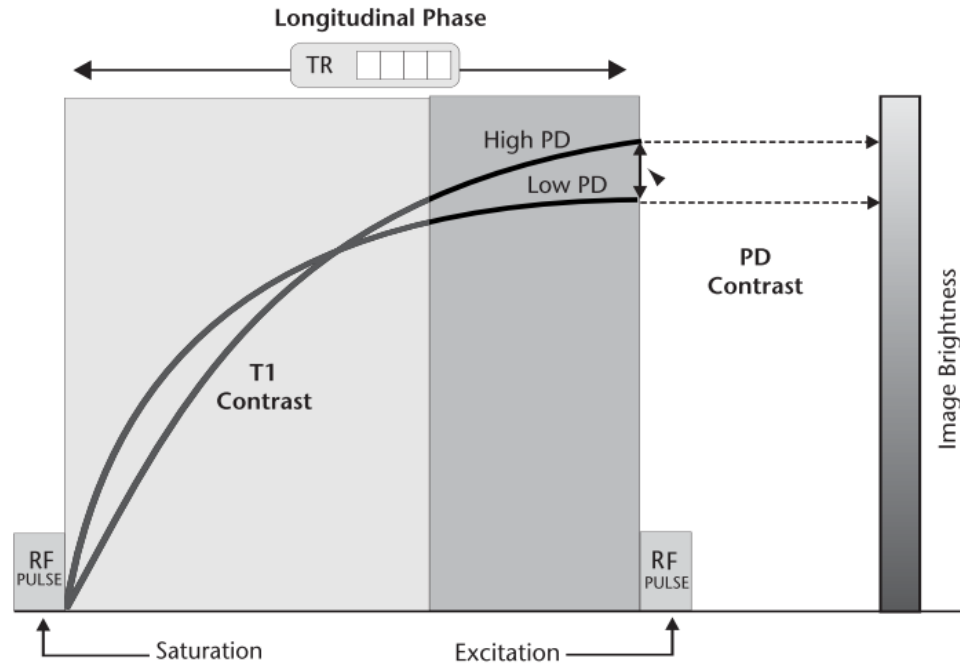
Proton density weighted MRI imaging. Taken from Sprawls.⁴⁶
